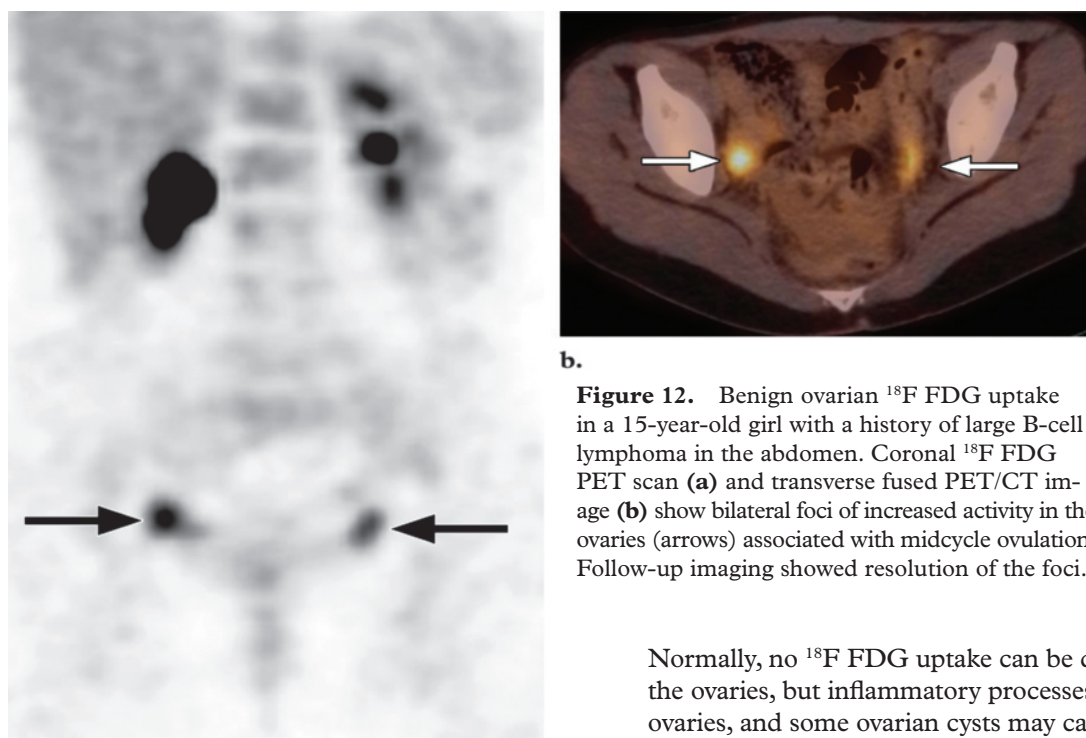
Benign ovarian ¹⁸F FDG uptake in a 15-year-old girl with a history of large B-cell lymphoma in the abdomen. Coronal ¹⁸F FDG PET scan (a) and transverse fused PET/CT image (b) show bilateral foci of increased activity in the ovaries (arrows) associated with midcycle ovulation. Follow-up imaging showed resolution of the foci.
